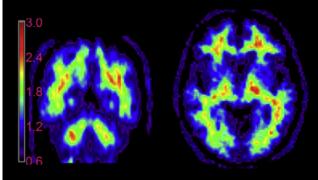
Representative [18F]AV-45 PET images. Average of two consecutive 5 minute PET brain images (obtained 50–60 minutes after injection) from a 77-year-old female, a mild AD patient with an MMSE of 24 (top) and an 82-year-old male, a cognitively healthy control with an MMSE of 30 (bottom), after an injection with 10 mCi [18F]AV-45. Experimental conditions and imaging and computational parameters were identical for the two subjects. Counts are shown as ratio to the average of the grey matter in cerebellum for each subject (standard uptake value regional [SUVR]) (figure courtesy of M Pontecorvo, Avid Pharmaceuticals).
